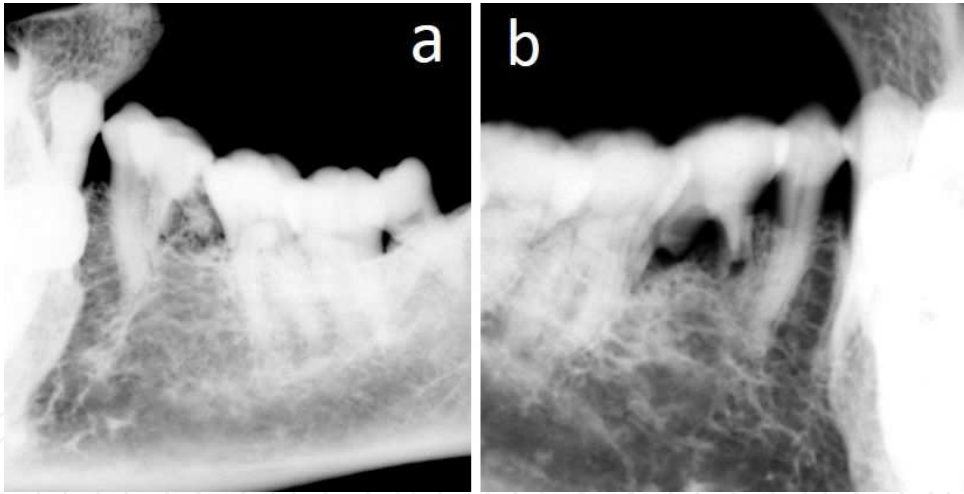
The lack of permanent second premolars are admitted in the roentgenograms. a: right side, b: left side, respectively. a: right mandibular condyle is normal. b: left mandibular condyle has caused the deformity by TMJ arthritis.
